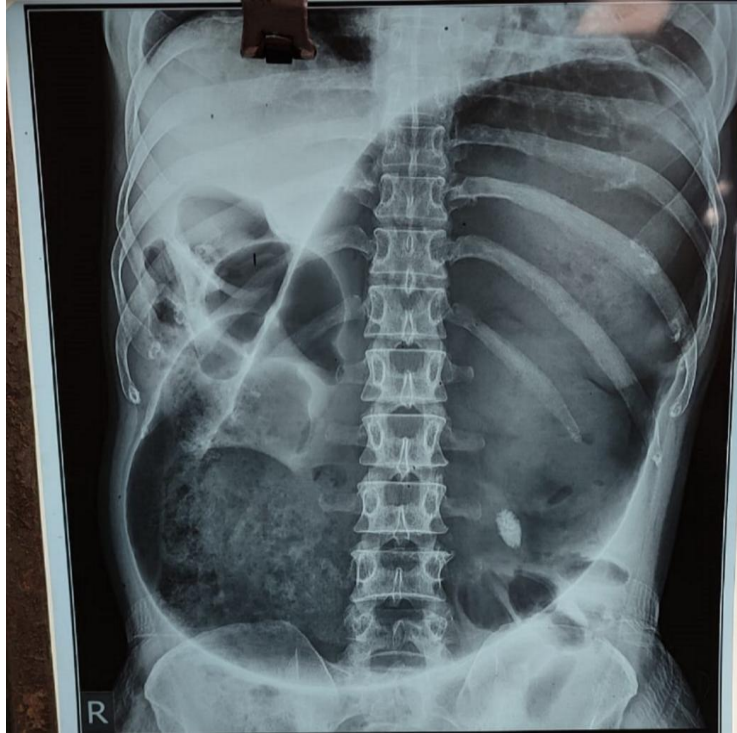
X-ray chest and abdomen showing massive gastric dilation
